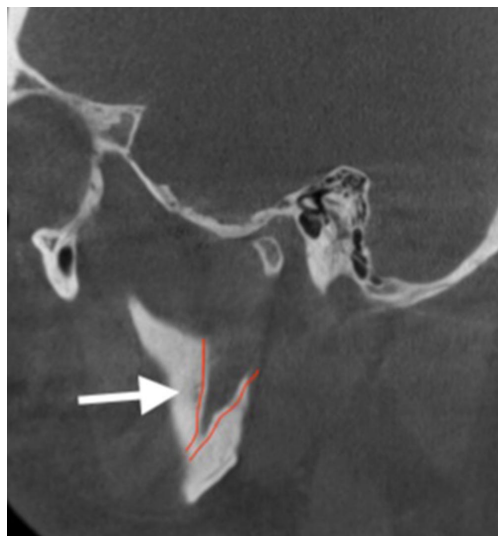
Sagittal view of CBCT imaging showing the outline of the funnel-shaped mandibular canal.
